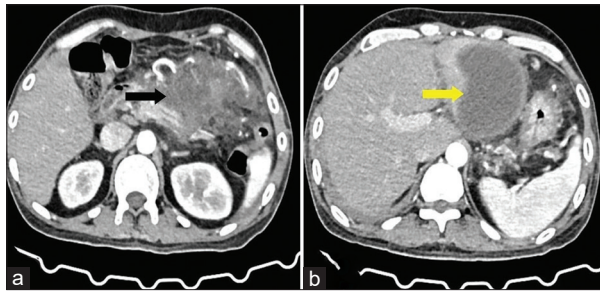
(a) Contrast-enhanced computed tomography abdomen showing pancreatic and peripancreatic necrosis (black arrow), (b) showing pseudocyst in relation to left lobe of liver (yellow arrow)
